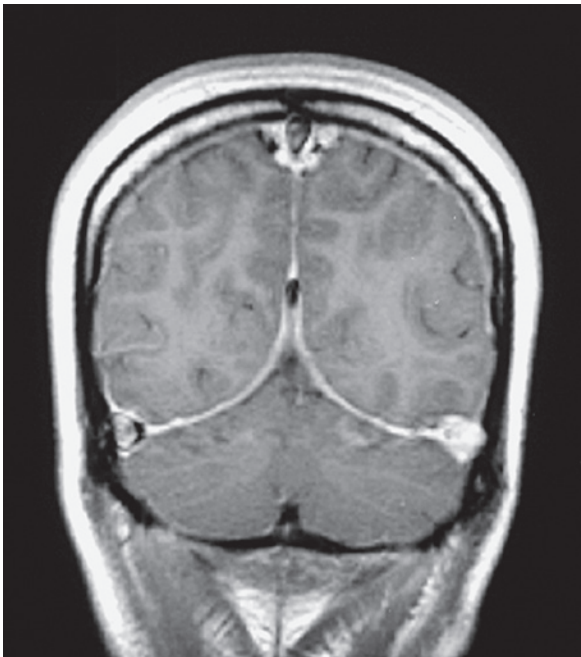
Magnetic resonance imaging (MRI) of superior sagittal sinus thrombosis: coronal T1-weighted post-contrast MRI; patient developed a sinus thrombosis following protracted labour and delivery.
